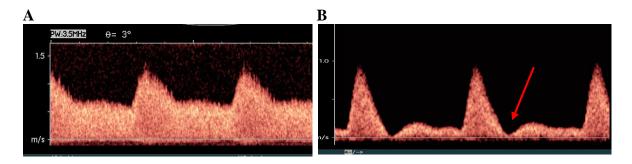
Pulsed-wave Doppler images showing blood velocity waveforms of the uterine arteries (UtA). Normal UtA blood flow velocity waveform (A), and abnormal UtA blood flow velocity waveform with diastolic notch indicated by the red arrow (B).
